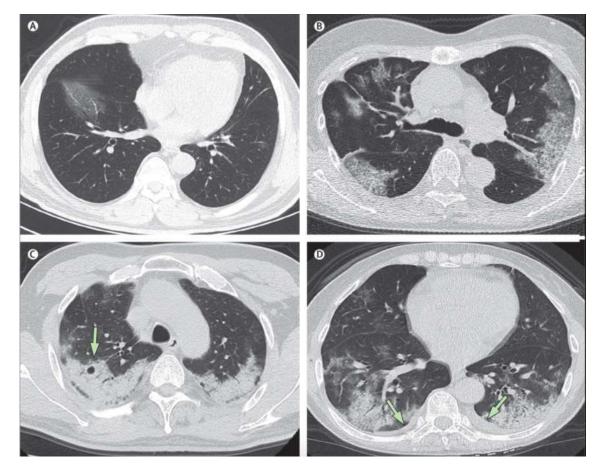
CT changes in COVID-19 (A) Focal ground-glass opacity associated with smooth interlobular and intralobular septal thickening in the right lower lobes. (B) Bilateral, peripheral ground-glass opacity associated with smooth interlobular and intralobular septal thickening (crazy-paving pattern). (C) Bilateral and peripheral predominant consolidation pattern with a round cystic change internally (arrow). (D) Bilateral, peripheral mixed pattern associated with air bronchograms in both lower and upper lobes, with a small amount of pleural effusion (arrows).
